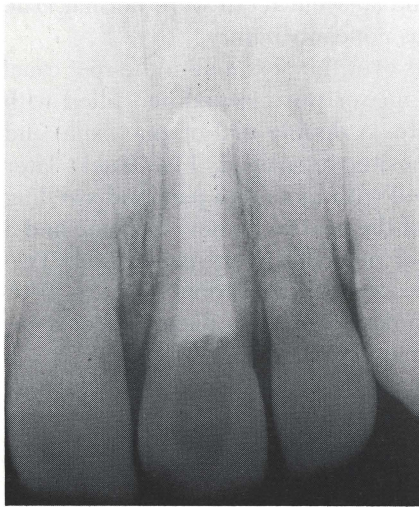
Radiograph at time of endodontic filling.
